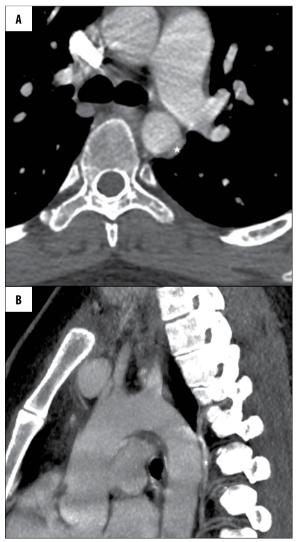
CT angiography of the aorta. (A, B) — MPR reconstruction. (C) — 3D reconstruction. Pseudoaneurysm (arrow).
